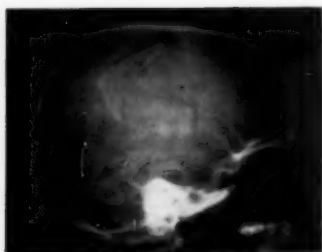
Right lateral skull roentgenograph of patient R. B., showing multiple fracture lines, one of which extends downwards into the posterior fossa. In the parietal region, the overlapping of the bone gives the commonly known effect characterizing a depressed skull fracture.
